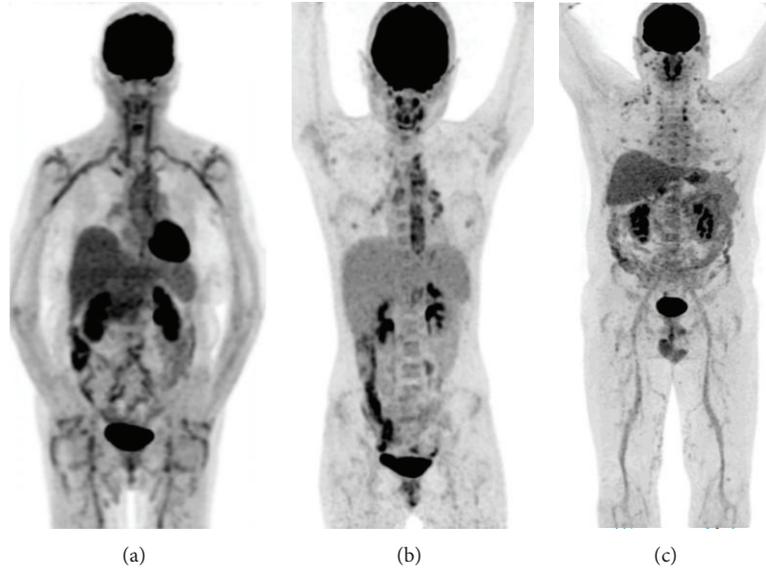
FDG-PET examples of vasculitis: (a) giant cell arteritis and polymyalgia rheumatica: high FDG uptake in the large vessels (aorta, subclavian arteries, carotid arteries, iliac arteries, and femoral arteries) accompanied by high uptake in the large joints (shoulders and hips), (b) Takayasu's arteritis: high FDG uptake located more centrally (aorta and main branches in the thoracic region) and in this case uptake in reactive lymph nodes in mediastinum and hili (confirmed by biopsy), and (c) polyarteritis nodosa and polychondritis: high uptake in the medium- and small-sized arteries (best visible in the legs) accompanied by uptake in the nose, the ears, and the costochondral regions.
